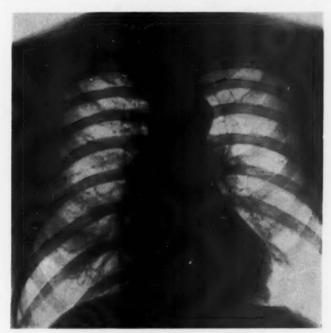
Chest x-ray, 1946.
